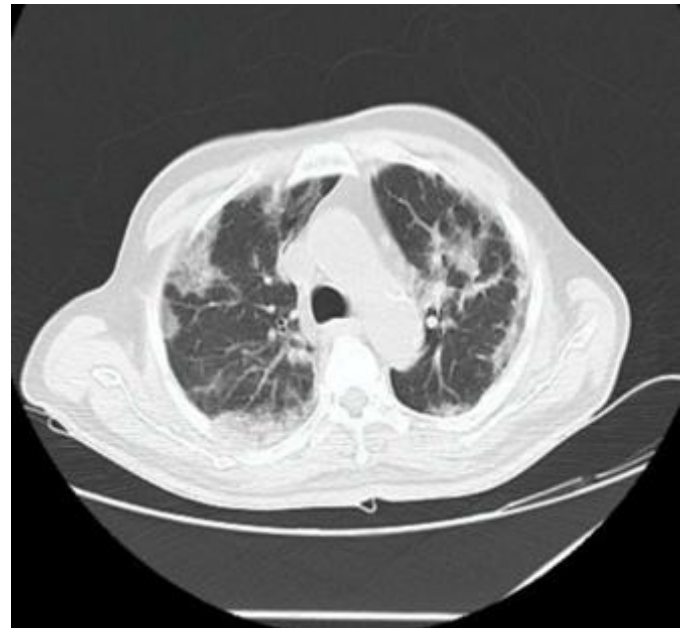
CT chest showing GGOs
